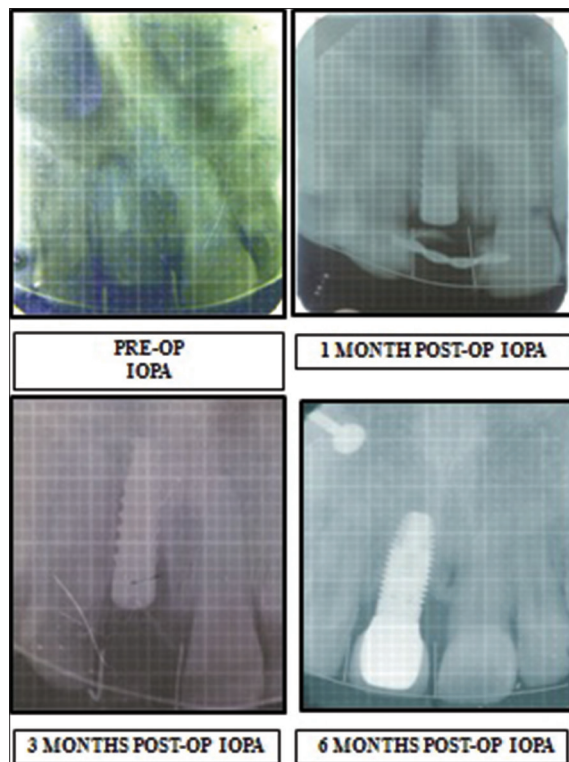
Radiographic assessment
